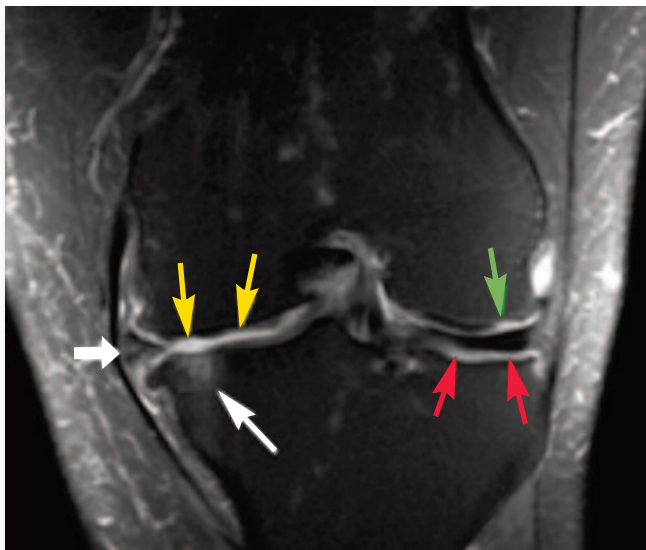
Coronal fat-suppressed proton density-weighted MRI (performed the same day as Figure 2a) showing subchondral bone marrow lesion (narrow white arrow) at the medial tibial plateau just subjacent to a focal full-thickness cartilage defect. There are multiple partial thickness defects of the medial femoral condyle cartilage (yellow arrows). Surprisingly, there are more extensive focal full thickness cartilage defects (green arrow) at the lateral femoral condyle and almost complete denudation (red arrows) subchondral bone at the lateral tibia, as opposed to a radiographically normal appearing lateral tibiofemoral joint space width. Indeed, most of the joint space narrowing of the medial tibiofemoral joint is secondary to a partially macerated and extruded medial meniscus (thick white arrow). There is attrition of the medial and lateral tibial plateaus and marginal osteophytosis.
